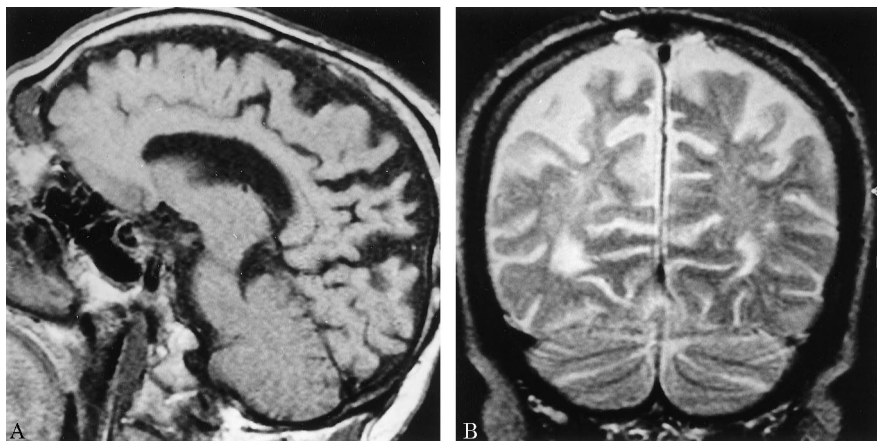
MRI of 66-year-old patient with corticobasal degeneration signs more prominent on left. T1-weighted sagittal section of right hemisphere (A) shows atrophy in posterior frontal and parietal regions. T2-weighted coronal section (B) shows cerebral atrophy, more severe on the right.
